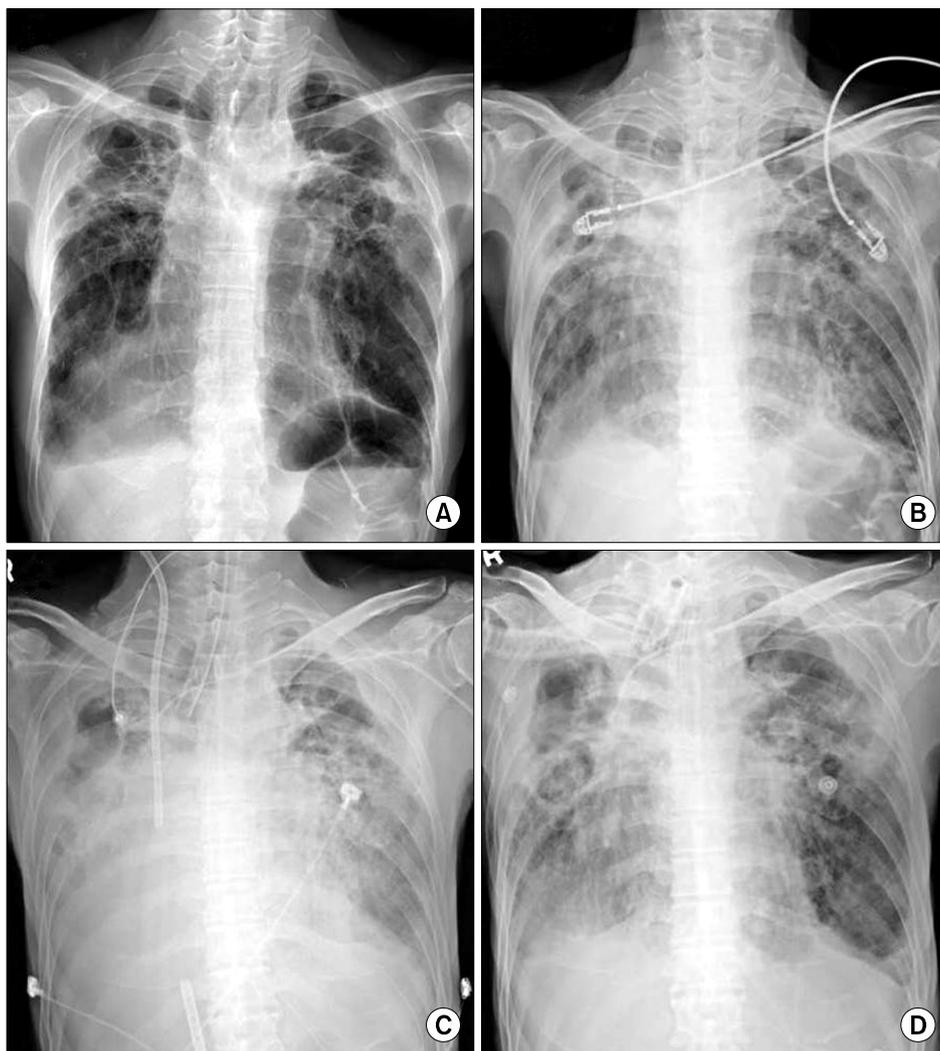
(A) Chest radiography obtained two months prior to admission showed pulmonary lesions that were destroyed by pulmonary tuberculosis. (B) On admission, the patient's chest radiography revealed increased bilateral pulmonary infiltrates. (C) Along with collapse of right middle and lower lung due to massive hemoptysis, a right femoral drainage cannula and a right carotid return cannula were inserted for ECMO. (D) At ECMO removal, chest radiography showed loss of atelectasis on the right lower lung field with decreased pneumonic infiltration.
